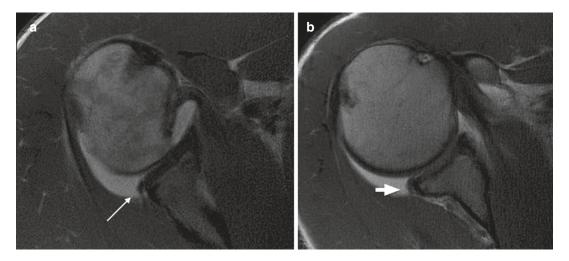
(a) Axial cut, proton density MRI images showing posteroinferior labrum degeneration and tearing (*arrow*), and (b) inferior blunting of the posteroinferior margin of the labrum (*arrowhead*)
